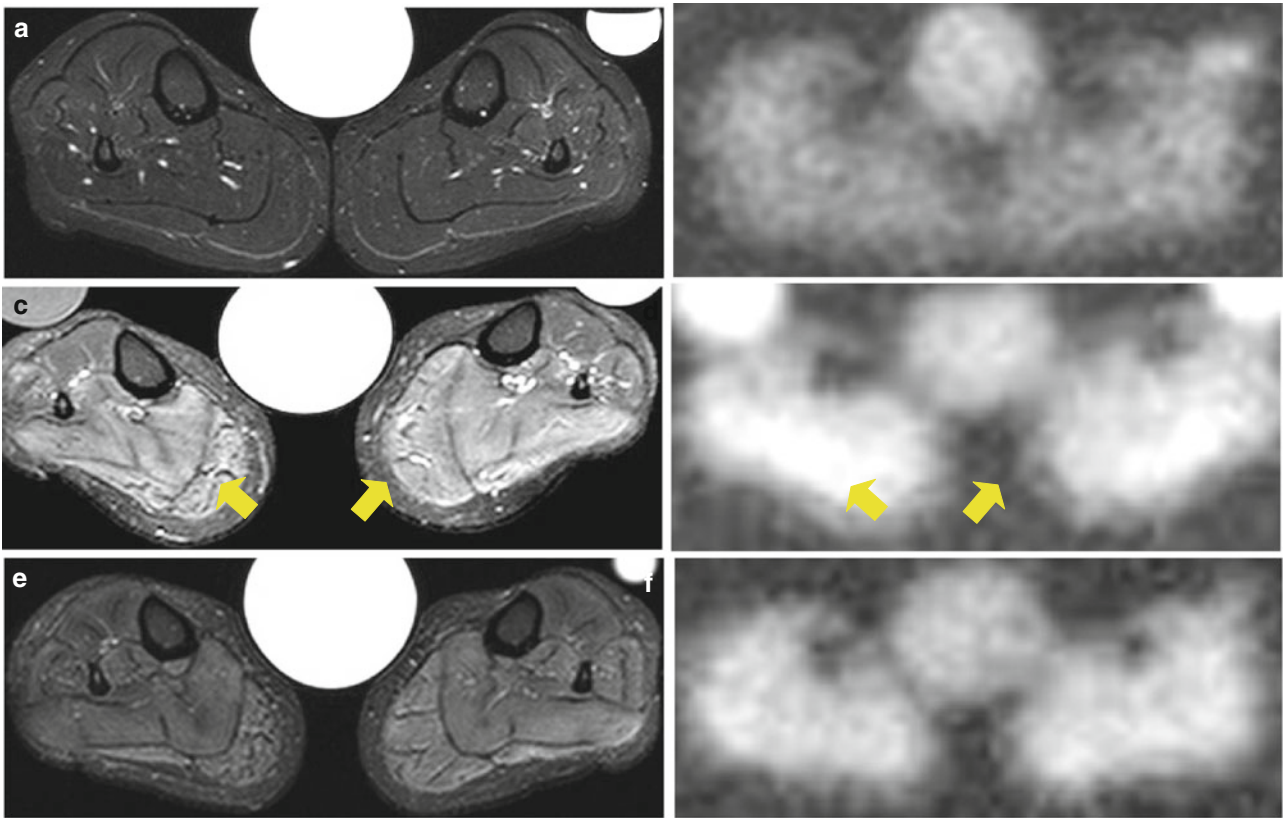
Axial ^{23}Na MRI of both lower legs in the same patient of Fig. 9 prior and post provocation by cooling of the left lower leg. No relevant changes of the overall sodium concentration are evident as assessed by a spin density image contrast, prior (a) and post provocation (b). ^{23}Na T1-weighted image contrast prior (c) and post provocation (d): after provocation, a slight signal increase within the left calf is ascertainable (arrows in d). ^{23}Na inversion recovery sequence prior (e) and post provocation (f): the signal increase in the left calf is clearly visible (arrows in f), and is probably caused by a
